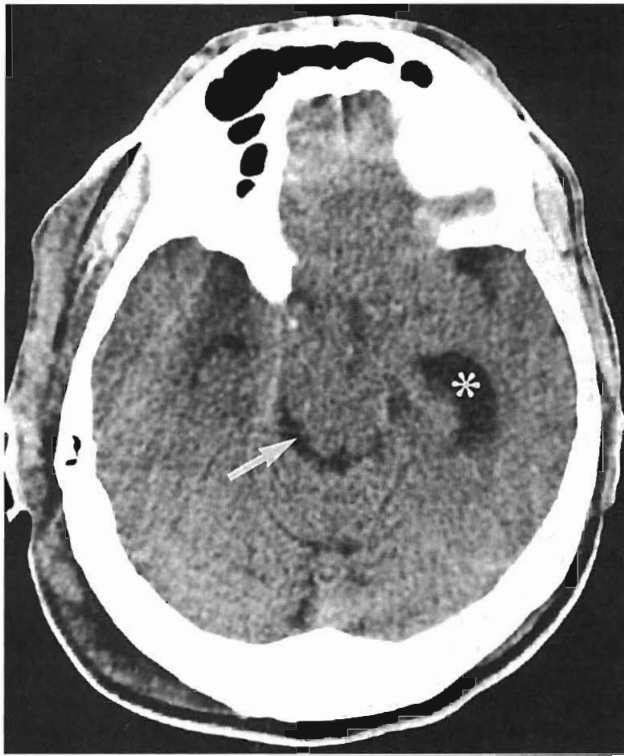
Right descending transtentorial herniation in a patient with a large right parietal subdural hematoma. Axial non-contrast-enhanced CT scan of the head at the level of the midbrain shows that the ipsilateral subarachnoid cistern is widened (*arrow*), and the contralateral subarachnoid cistern is obliterated because of brainstem rotation. The left temporal horn is also dilated (*asterisk*), indicating trapping of the left lateral ventricle.
